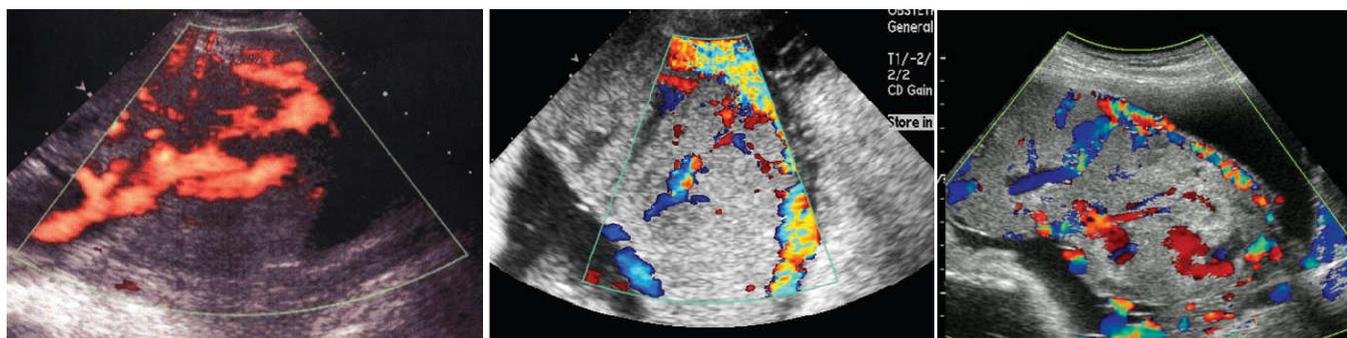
Shows most of color doppler finding in placenta accreta
